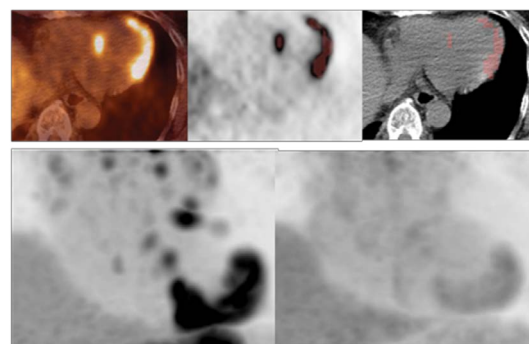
A 66-year-old male who was a responder to steroid therapy for CS. From ¹⁸F-FDG PET/CT fusion images before steroid therapy (upper left), the volume of the LV wall with SUV ≥ 4.0 is automatically extracted (upper centre) and displayed on the CT images (upper right). The SUVmax, MV and TLG in the LV wall are 11.3, 50 cm³ and 391 g, respectively. SUVmax is high, suggesting a non-responder. However, TLG could predict a responder. Maximum-intensity-projection images of ¹⁸F-FDG PET/CT before steroid therapy (lower left) and 5 months after initiation of steroid therapy (lower right) are presented. The patient has improvement of heart failure and ¹⁸F-FDG accumulation of the LV wall has almost disappeared. The SUVmax and TLG in the LV wall after steroid therapy are 3.2, 0 cm³ and 0 g, respectively.
